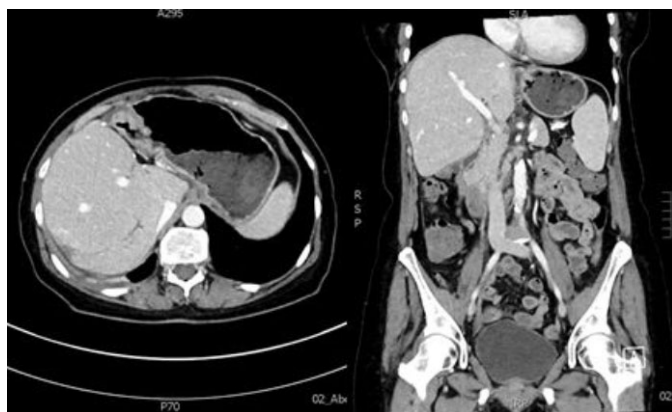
CT venous phase abdomen of resolved hepatic necrosis with hepatic hyperplasia—22 months (OPD follow-up).
